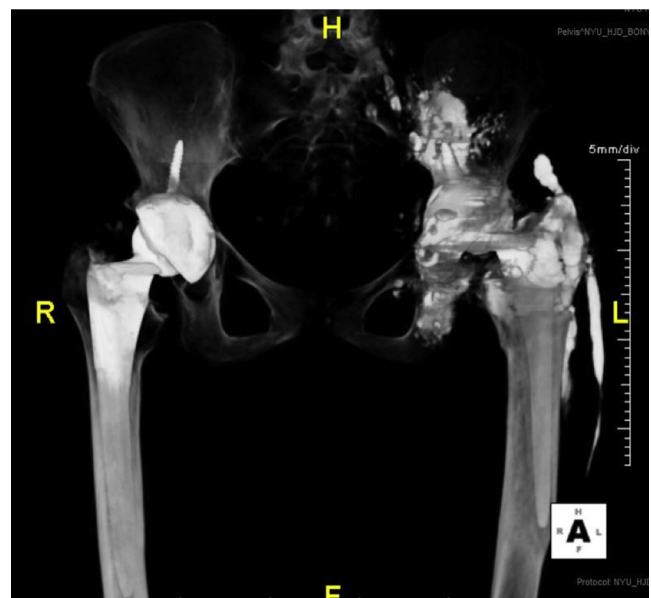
Three-dimensional computed tomography showing lateral loss of the normal spherical contour of the femoral head with eccentric positioning within the acetabular cup, varus positioning of the femoral stem with global lucency at the femoral prosthetic/bony interface, and extensive metallosis extending both superiorly and inferiorly from the greater trochanter along the lateral soft tissues of the thigh.
